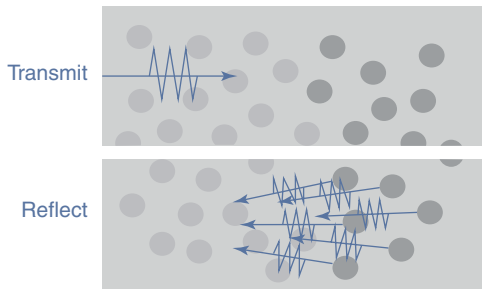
Principle of 'backscattered ultrasound' in a heterogeneous medium
